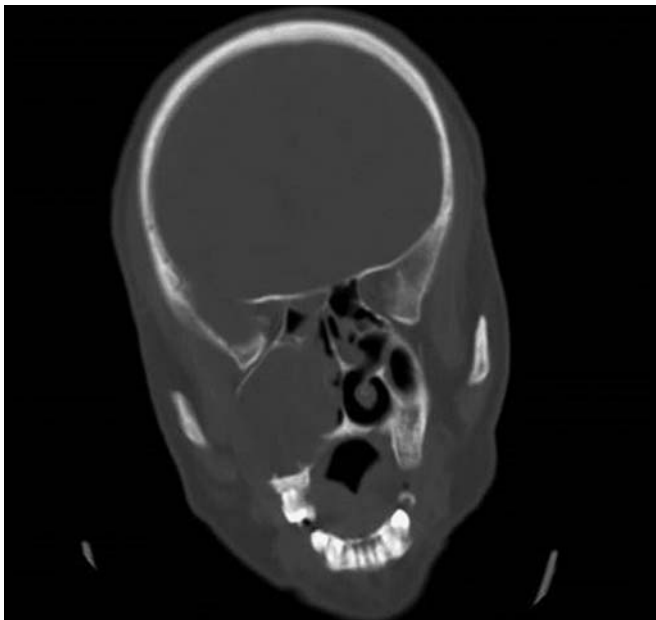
Coronal CT showing giant mucocele in the right nasal cavity.
